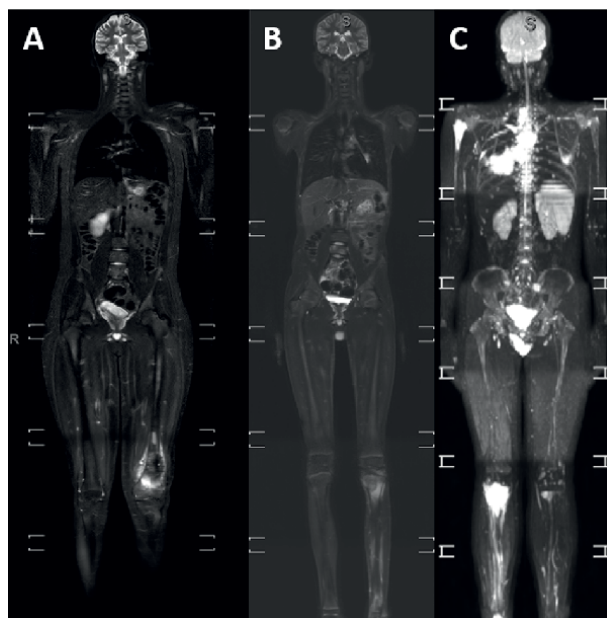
Total body MRI. (A) patient with conventional osteosarcoma at the distal end of the femur; (B) patient with Ewing's sarcoma of the first metatarsal, observing metastasis in the proximal end of the tibia, and (C) patient with lung cancer and multiple bone metastases.
